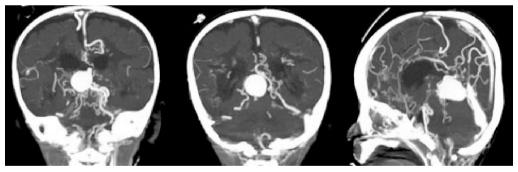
CT Cerebral Angiography (b) Coronal and sagittal MIP images
